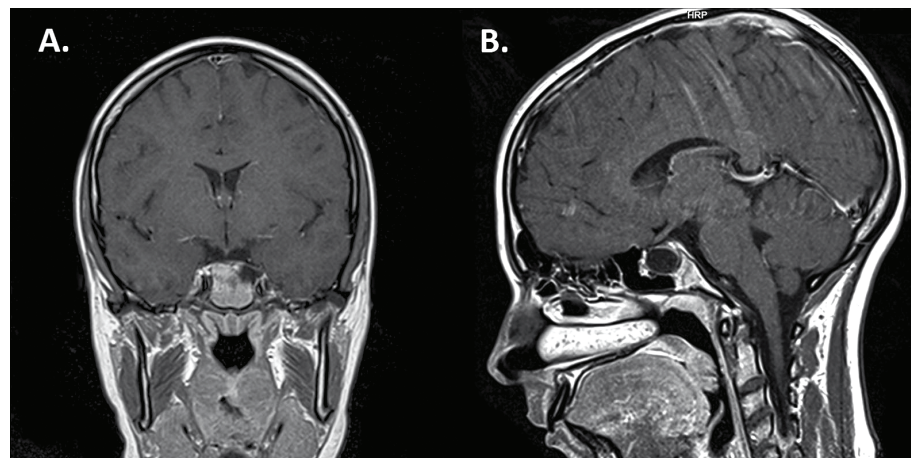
After two years completion of cabergoline treatment, an impressive shrinkage with liquefaction of the mass is observed (1.43 × 2.14 × 1.93 cm) in contrast-enriched coronal (A) and sagittal (B) MRI planes.
